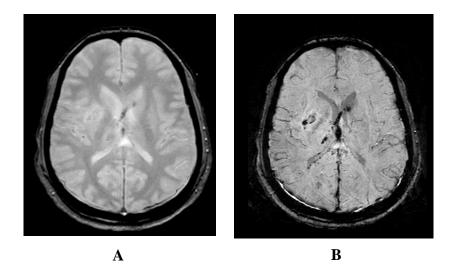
High resolution (1.0 mm³) SWI comparison to conventional GE MRI in the brain.
